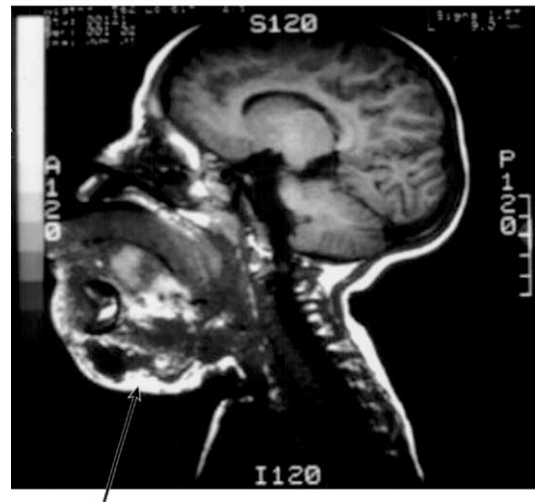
Craniofacial magnetic resonance image of a child with an extensive cervical lymphatic malformation involving the tongue base and floor of mouth.
